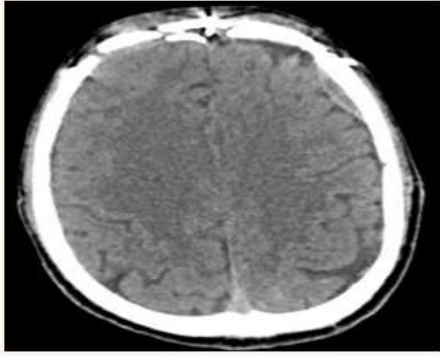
CT Brain post seizure episode - reduction in extradural and subarachnoid haemorrhage in comparison to previous study with no fresh pathology
